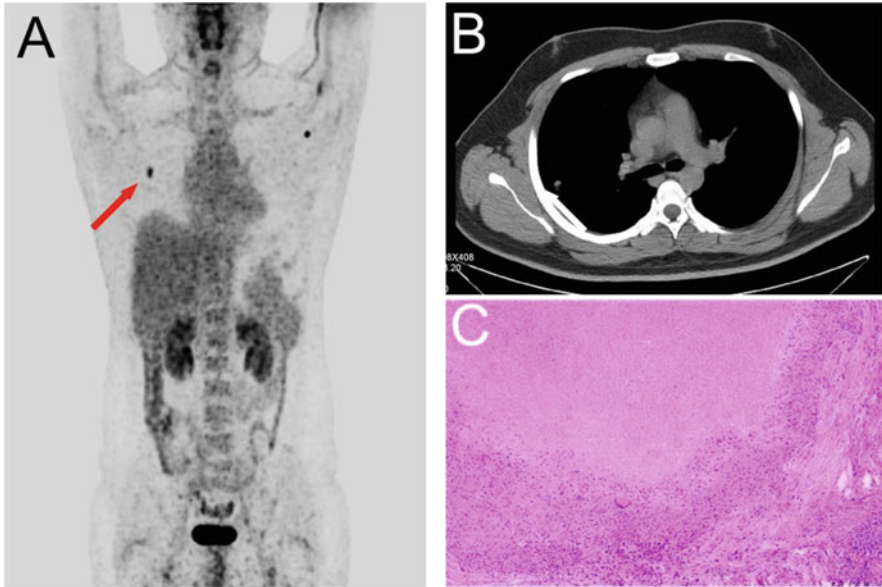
(a) ^{18}F -FDG PET/CT images demonstrated a 12.9-mm*7.7-mm mass of intensive FDG uptake in the right middle lung (*red arrow*) with $\text{SUV}_{\text{max}} = 5.33$. (b) Diagnostic CT image showed a 13-mm*6-mm nodule in the lateral segment of the right middle lung. (c) Routine pathology of the mass revealed “chronic granulomatous inflammation”
